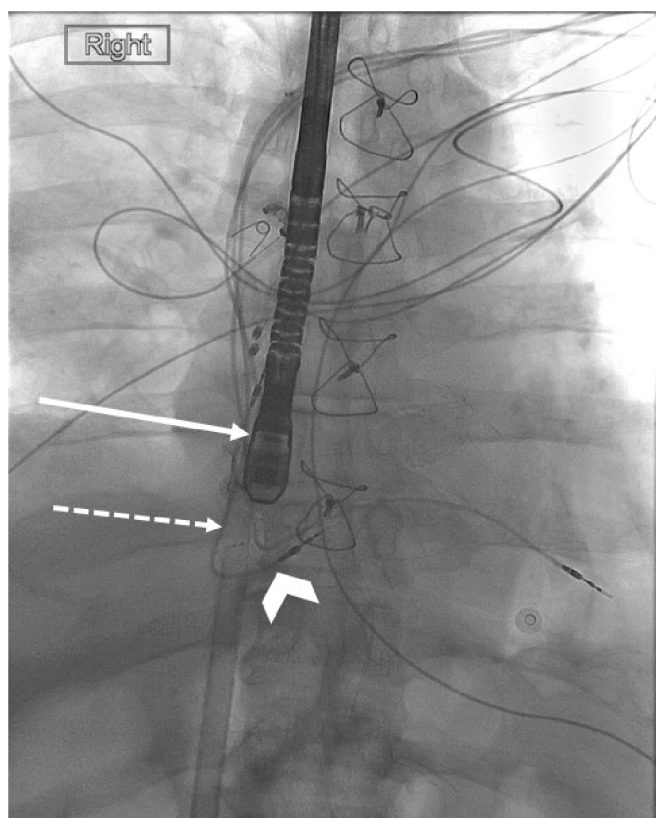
Fluoroscopic Image of Vacuum-Assisted Thrombectomy (VAT) in the Right Heart. Under a combination of transesophageal echocardiographic (TEE) and fluoroscopic guidance, the AngioVac system was used to remove the right atrial pacemaker lead-associated mass. Fluoroscopic image, coronal view shows the coordination between the TEE probe (solid arrow) and right common femoral venous approach 180-degree angled 22 French cannula (dashed arrow) in the region of the right atrium and right atrial pacemaker lead (chevron).
